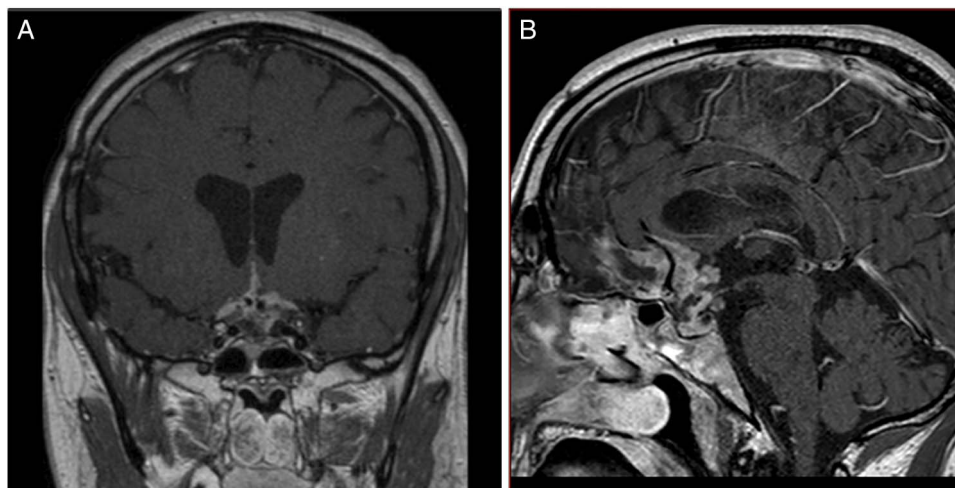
(A) MRI at 5 years of follow-up (coronal view). (B) MRI at 5 years of follow-up (sagittal view).
